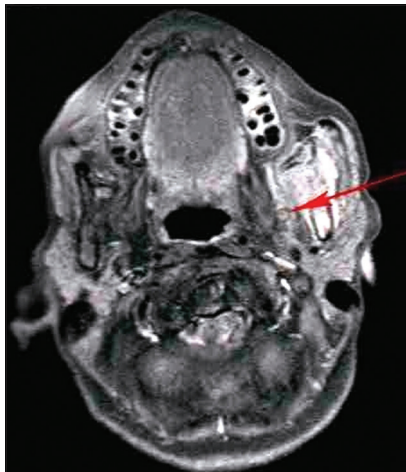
Peri-neural spread on magnetic resonance imaging image (axial view)
